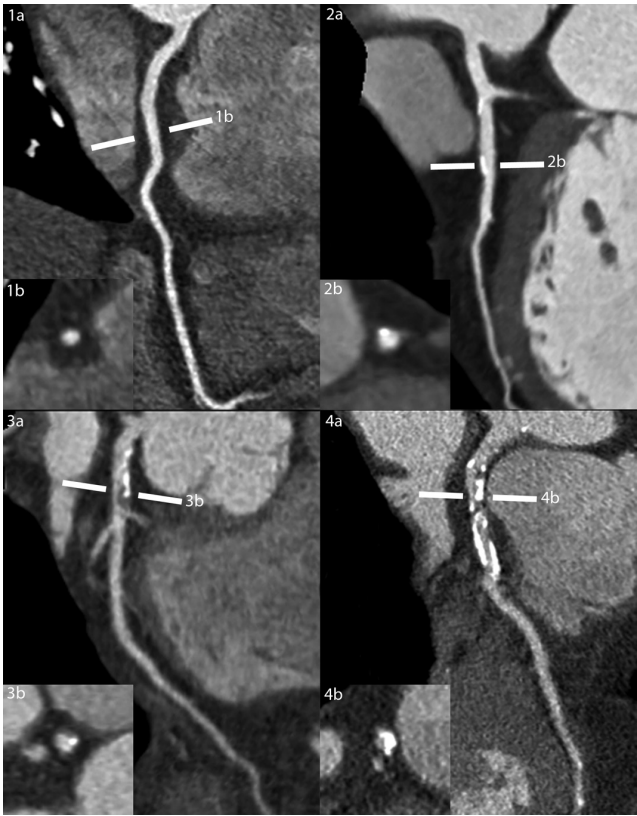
Curved Multi Planar Reconstructed (cMPR) CT images and cross sections of the left anterior descending coronary artery (LAD) of 4 asymptomatic patients with Familial Hypercholesterolemia showing a non-diseased vessel (1a, 1b), a non-obstructive calcified lesion (2a, 2b), an obstructive partly calcified lesion (3a, 3b) and an obstructive severely calcified lesion (4a, 4b).
